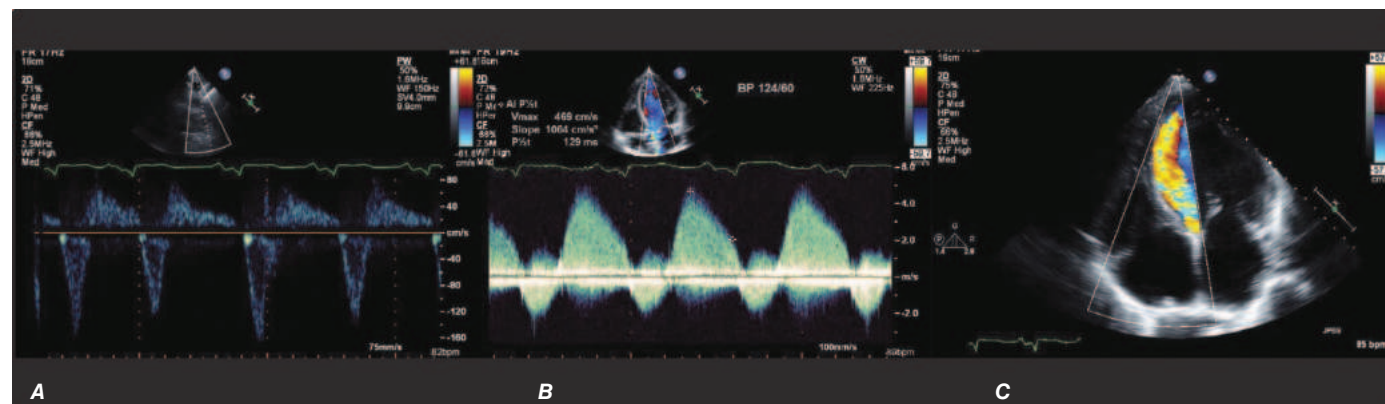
Three types of Doppler ultrasound. A and B. Pulsed and continuous wave Doppler waveforms with time on horizontal axis and velocity of blood flow on vertical axis. C. Color flow Doppler, where velocities are encoded by colors according to scale on right side of screen and superimposed on a two-dimensional grayscale image.
